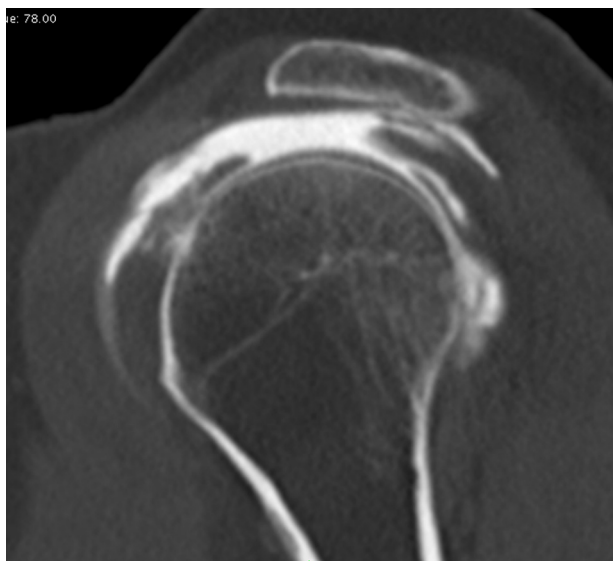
CT arthrogram. Sagittal view, showing the width of the supraspinatus tendon tear and posterior lamellar dissection of the infraspinatus tendon.
